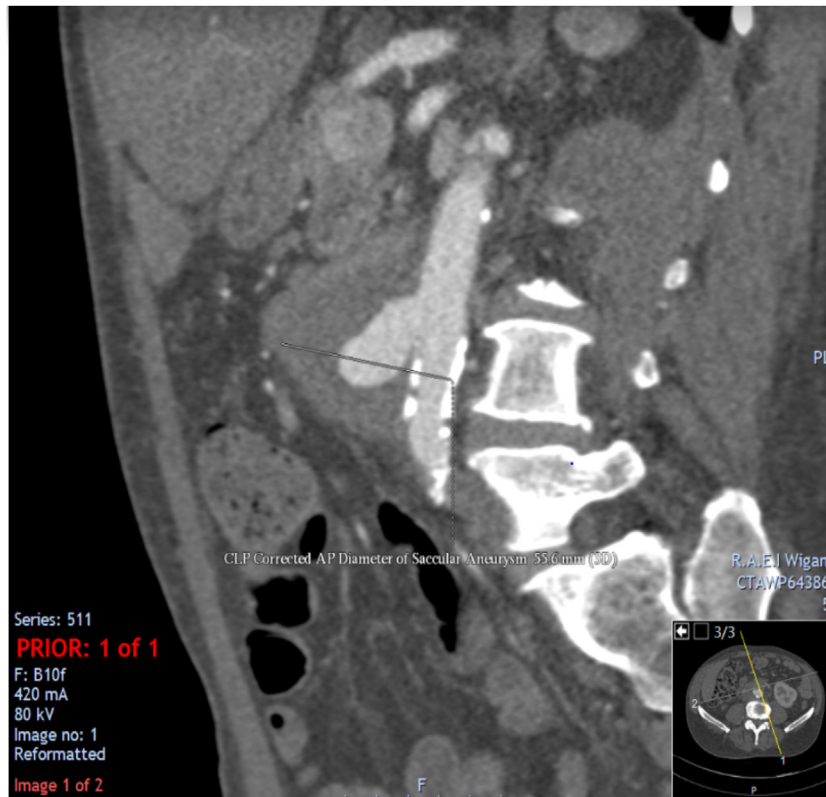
Computed tomography angiogram showing aneurysm of infrarenal aorta.
